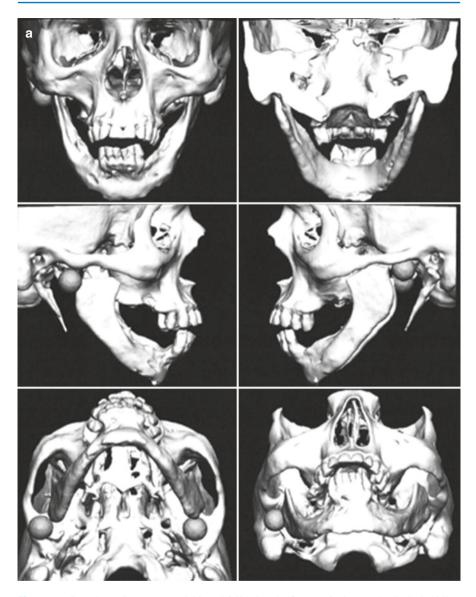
Case 4. (a) CT scan, acquisitioned following the first surgical stage that included bilateral remove ankylotic bone, condylectomies, coronoidectomies, and placement of silicone balls into the created bone gap. (b) CASS and VSP technology used to place the mandible into the final surgical position (orange mandible), superimposed on the CT scan in Fig. 7.15a. From this position, it will be determined if additional bone resection and preparation of the fossa and ramus are required
